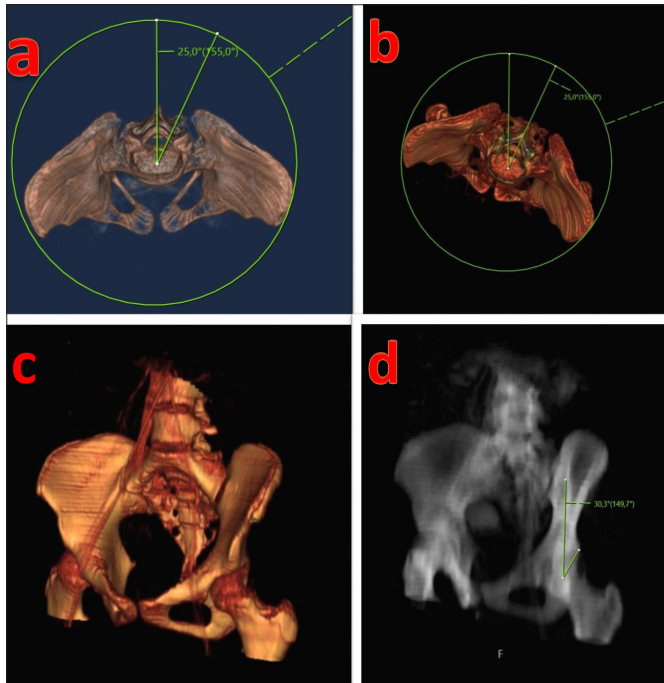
Obtaining a false profile image with 3D reconstruction: a) looking from the top, a circle that would be the central lumbar vertebra corpus was drawn, and the degree of rotation was determined angularly, b) with reference to the posterior spinous process, 25° of rotation was achieved as in positioning to the false profile, c) false profile position has been set, d) software reconstruction has realized to create an X-ray image
